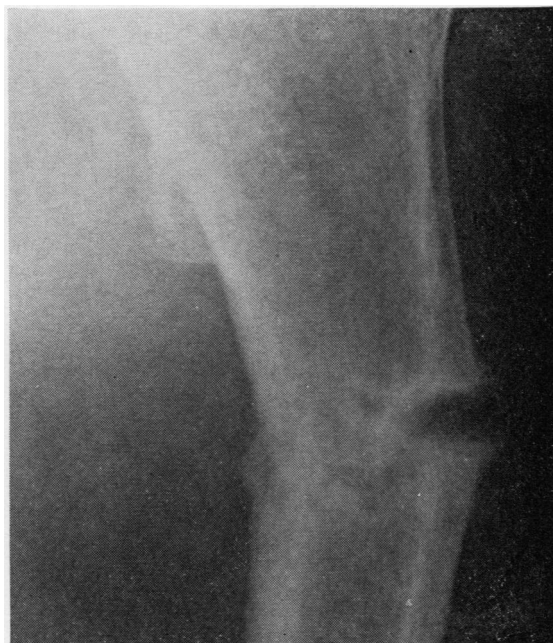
Case 2. Radiograph of left femur showing partial fracture.
